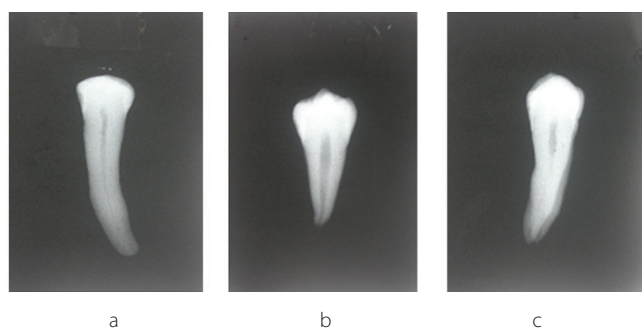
Radiographs obtained at 30 (a), 60 (b) and 90 (c) days following immersion of teeth in demineralizing solution to ensure development of carious lesions
